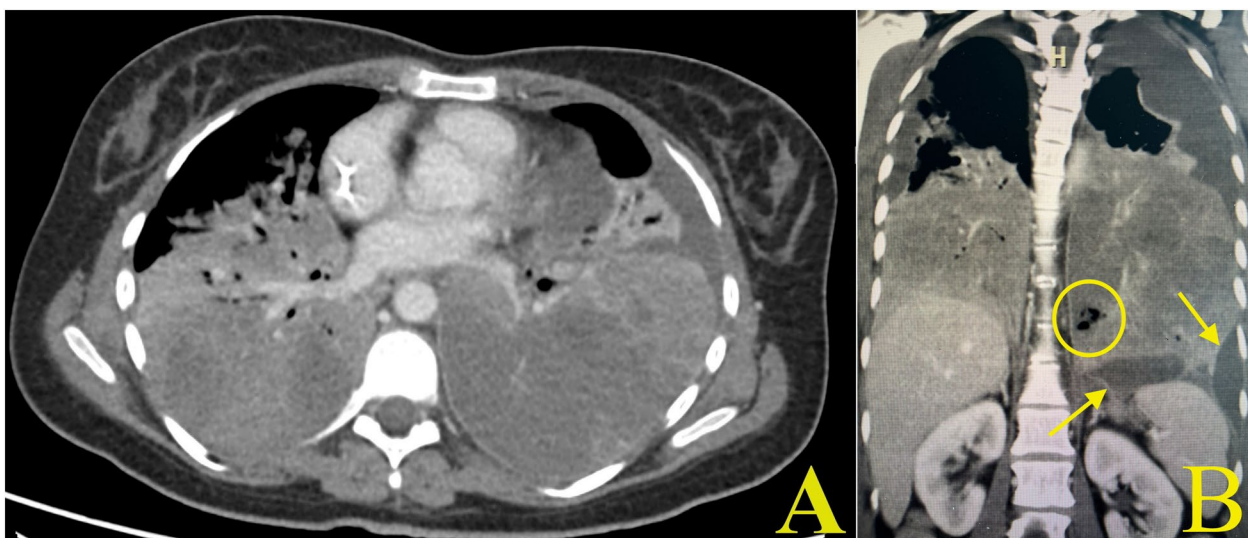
Admission computed tomography scans of transverse (A) and frontal (B) sections show extensive atelectasis bilaterally with edema of the non-aerated lung tissue. There is a fluidothorax on the left (arrows) and gas cavities (circle) as evidence of a decay process
